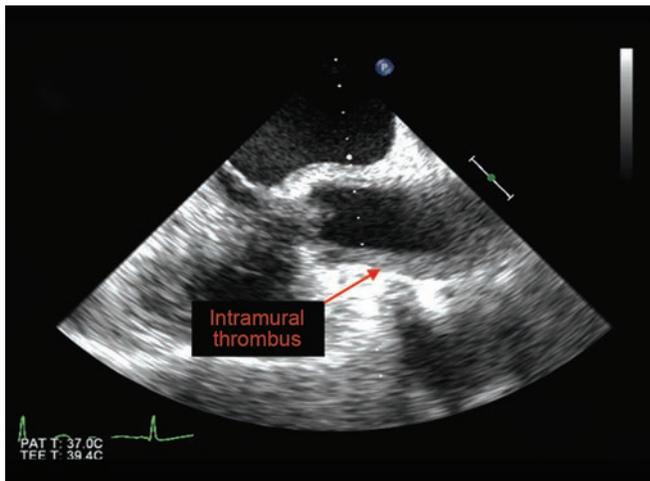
Transesophageal echocardiography (TEE) showing longitudinal view of the ascending aorta.
